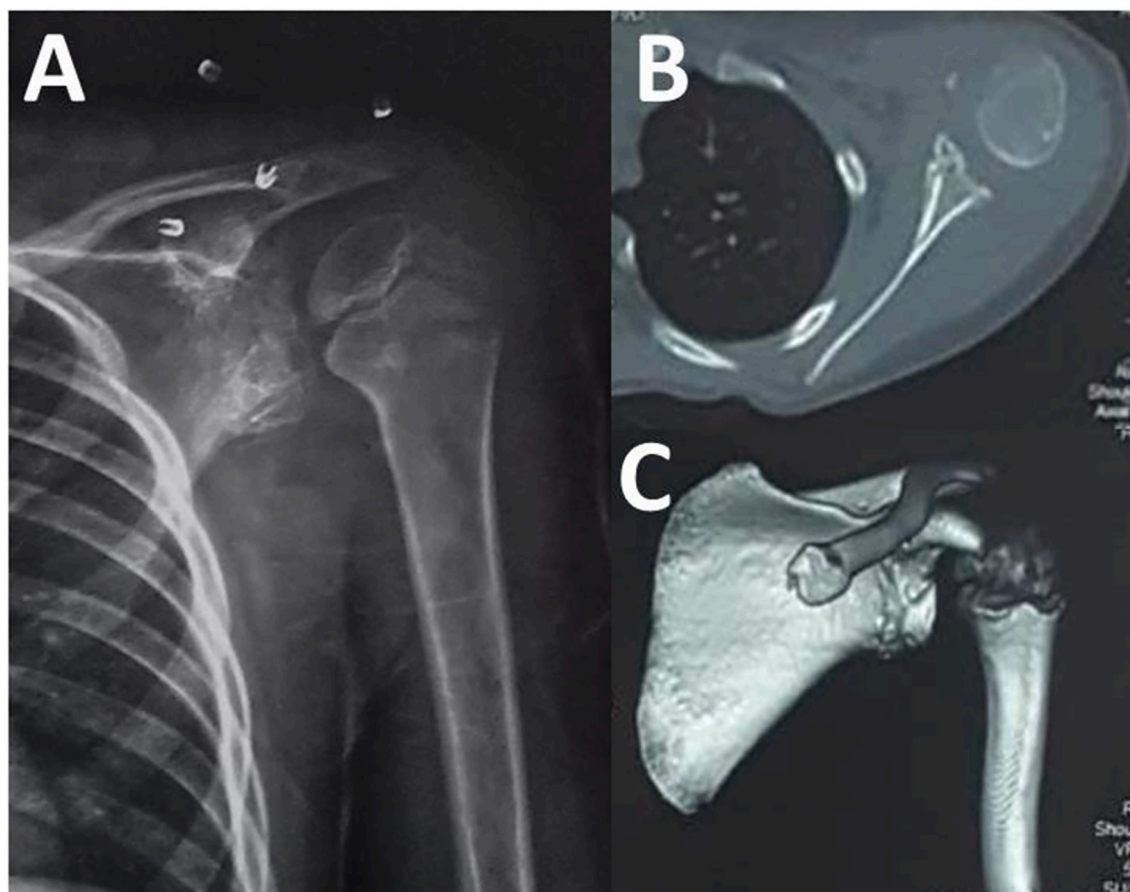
Healed GLAD lesion. A: AP view of the left shoulder after removal of the KW after two months. B: Axial CT view of the left shoulder confirming successful reduction and the healing of the GLAD lesion. C: 3D CT scan of the left shoulder confirming complete union of the GLAD lesion.
